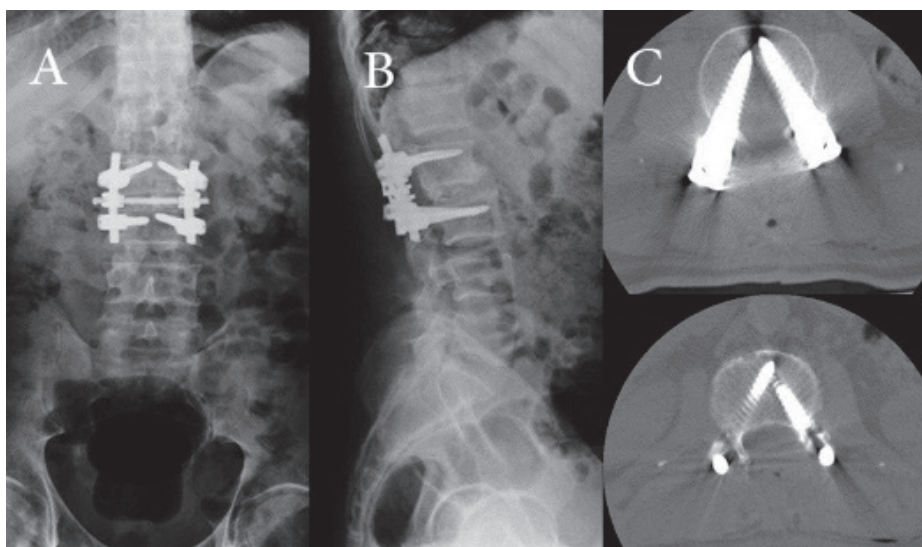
Postoperative anteroposterior and lateral radiographs, two rods, and one cross link are used.
